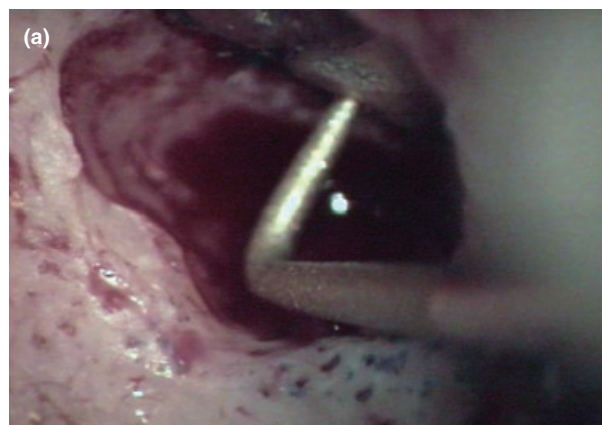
(a) and (b) – Retropreparation on the palatal root apices of tooth 14 with ultrasonic retrotips.
